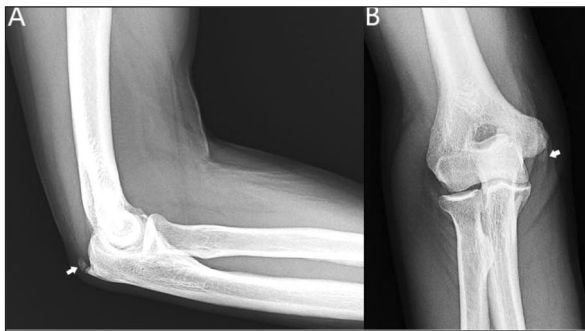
Lateral (A) and anteroposterior (B) radiographic images of the right elbow show amorphous calcified densities (arrows) in the soft tissue.
